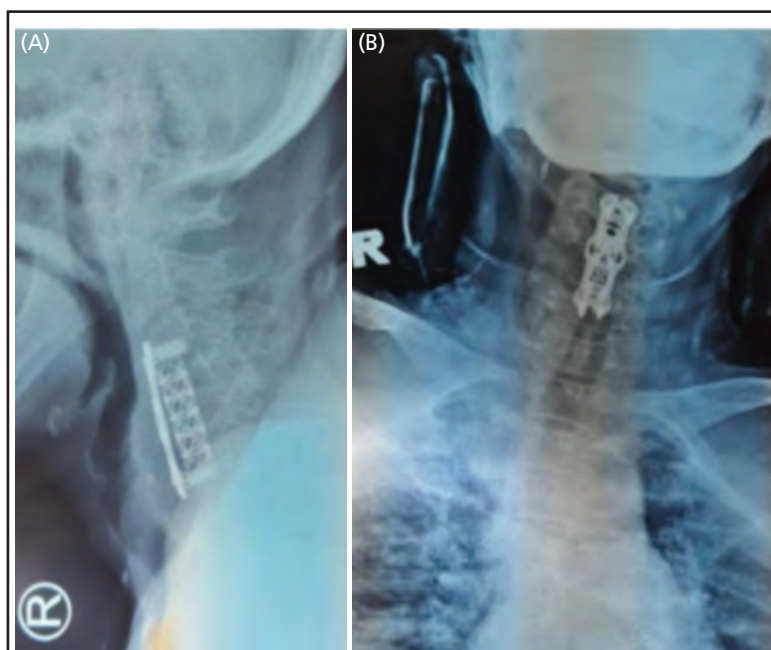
Showing lateral (A) and anteroposterior (B) view of immediate postoperative cervical X-ray
